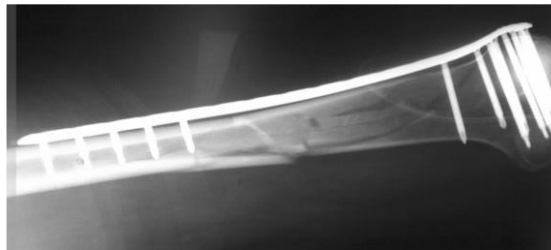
X-Ray of a locking plate (Kubiak, Fulkerson et al. 2006)
